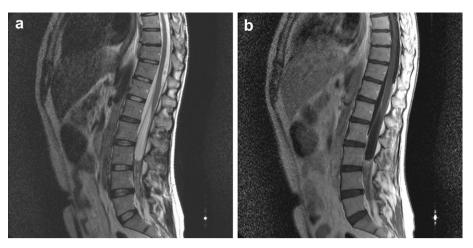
Sagittal T2 (a) and gadolinium enhanced T1-weighted (T1W) (b) MRI demonstrate pathologic enhancement and endocanalar pathologic tissue of the L4-S2 tract.
